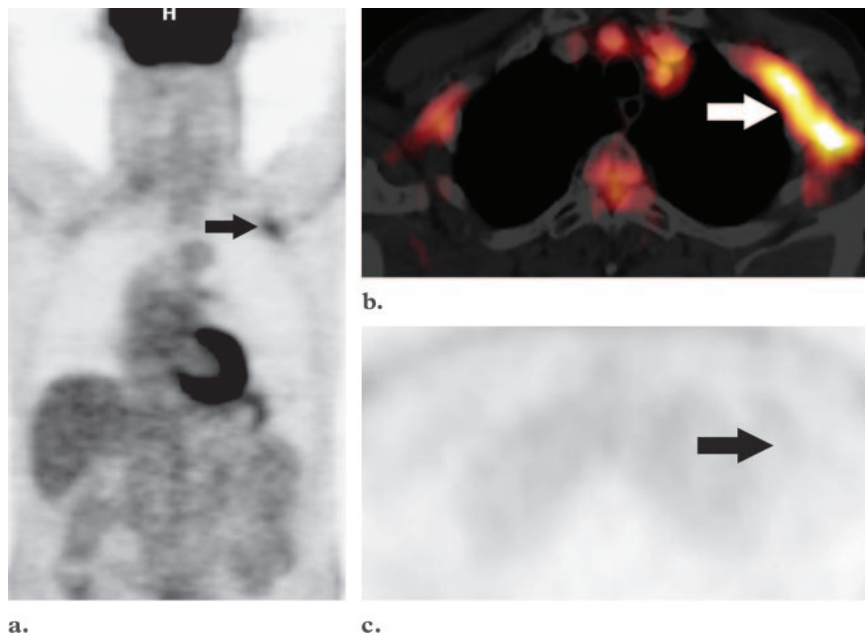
Linear CT attenuation artifact due to high-attenuation intravenous contrast material. (a) Coronal PET scan shows a focal area of intense FDG accumulation located in the left axilla (arrow) and mimicking an abnormal axillary lymph node. (b) Axial fused PET-CT scan helps localize the uptake to an area of dense contrast material in the left subclavian vein (arrow). (c) Axial uncorrected emission image reveals that the area of apparent FDG uptake in the axilla (arrow) is an artifact generated during the attenuation correction process. (Figure 27 reprinted, with permission, from reference 37.)
